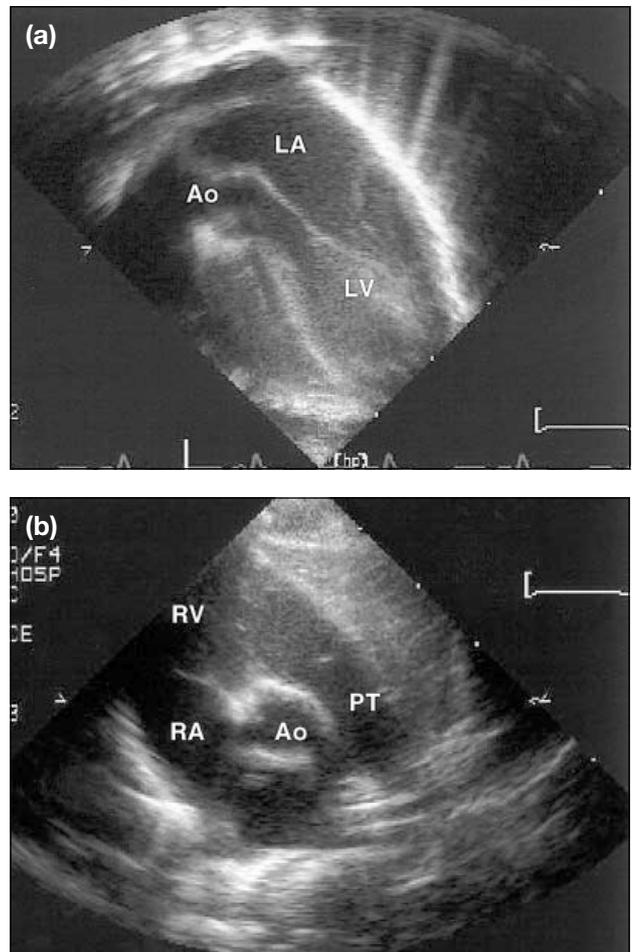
Echocardiograms showing normal crossing of the path of the two great vessels. (a) Apical long axial view which shows the left ventricle giving rise to the aorta. The vessel runs a relatively straight course towards the right shoulder; (b) parasternal short axis view showing the aorta in cross-section, being encircled by the anteriorly directed pulmonary artery which bifurcates into the left and right pulmonary arteries. *Abbreviations:* Ao = aorta; LA = left atrium; LV = left ventricle; PT = pulmonary trunk.
